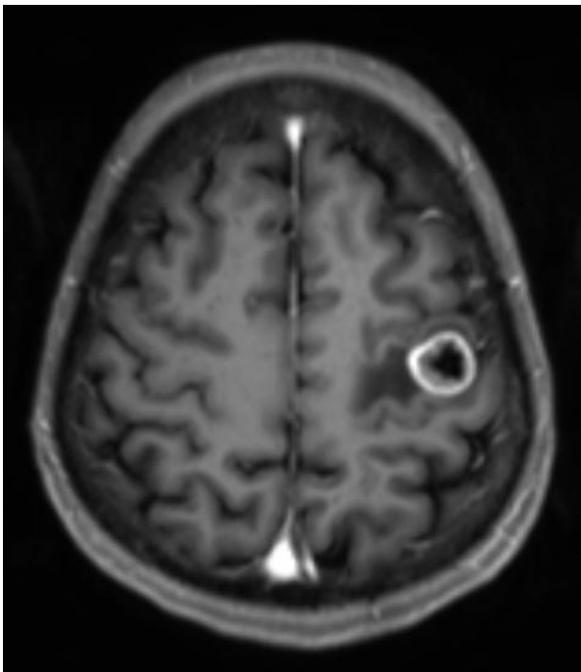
Pre-operative MRI scan
